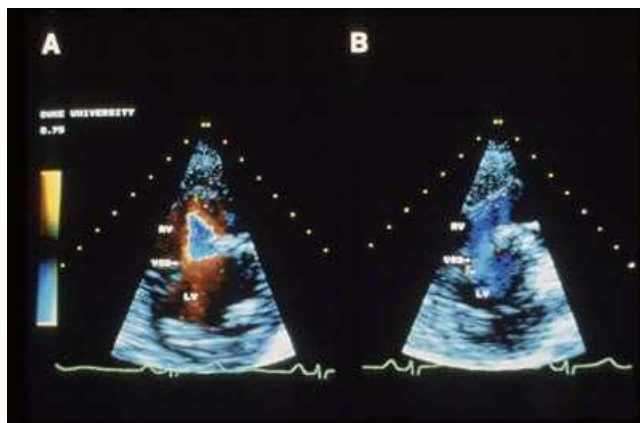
47 Left parasternal short-axis view of the left ventricle is seen in panel A where the left-to-right component of flow is shown through a very large ventricular septal defect. In panel B, right-to-left component of flow is visualized. A turbulence map was used.
